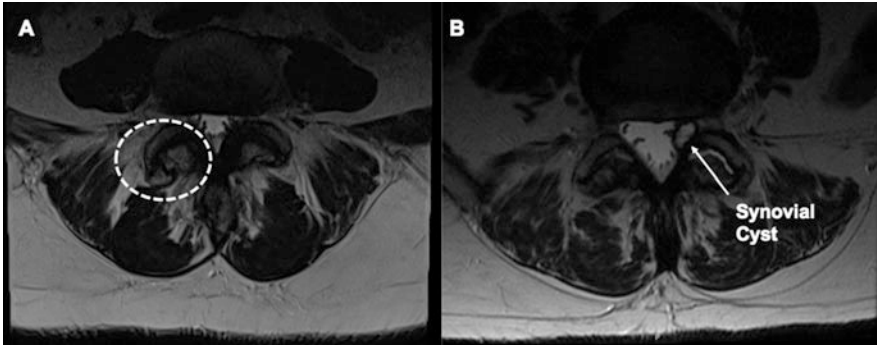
Axial T2-weighted MRIs of the lumbar spine demonstrating (a) spine facet arthropathy with osteophytes noted at the superior and inferior articulating facets. (b) Synovial cyst with impingement of spinal canal
